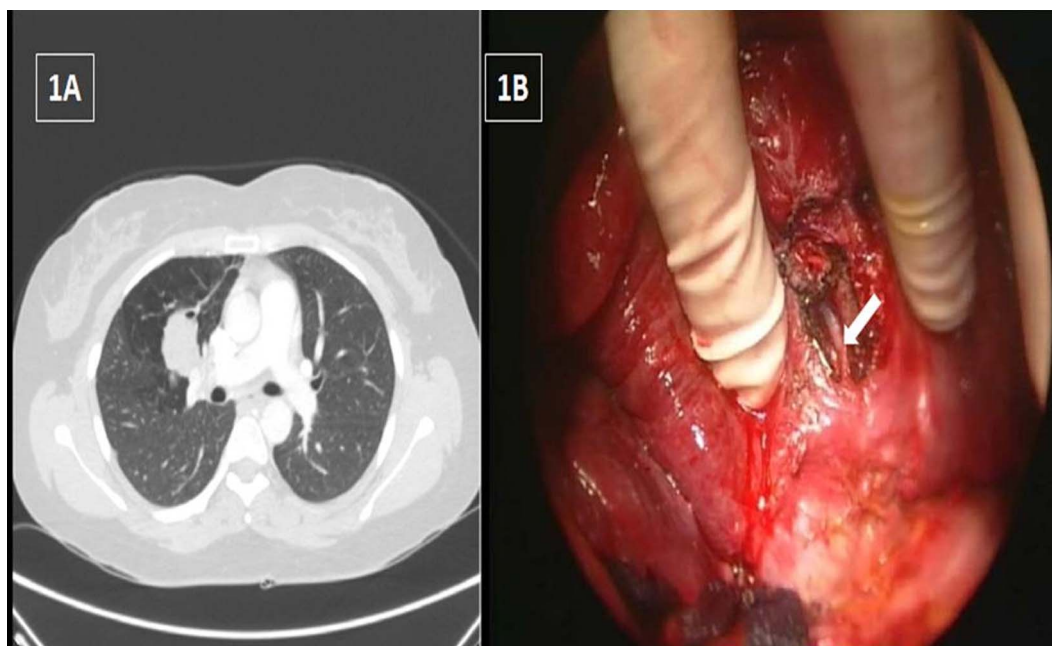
(A) High-resolution CT/MRI showing a 7×4.5 cm margined mass with an air bubble inside, and a hypoperfused area in the distal parenchyma. (B) After removing part of the cystic wall, a branch of superior pulmonary vein was visible (arrow).
